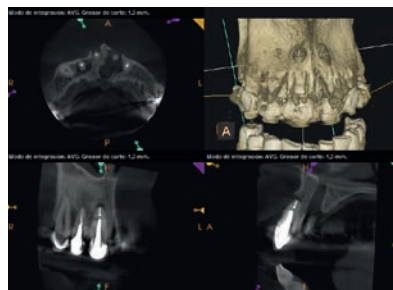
Upper right central incisor preoperative CBCT image.
